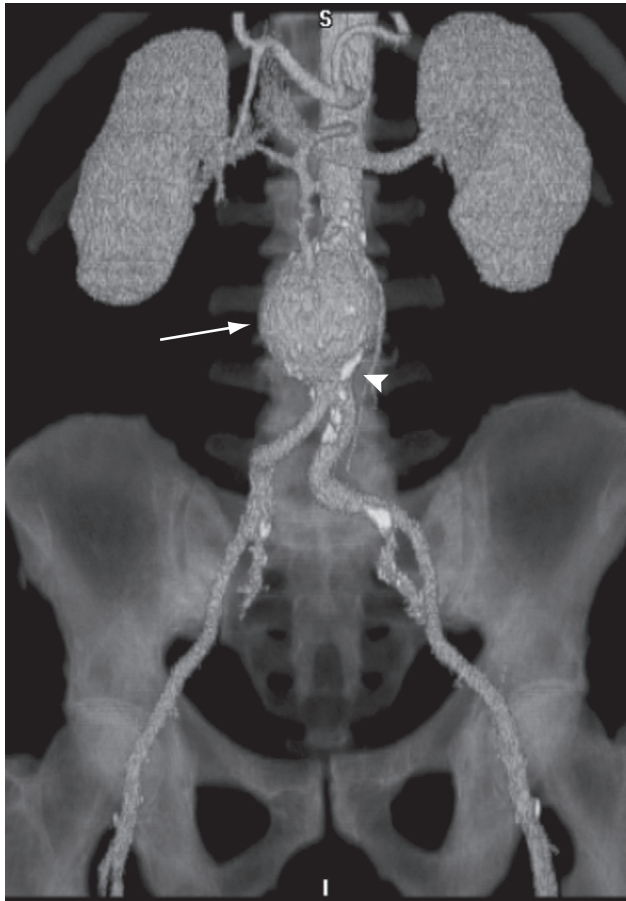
CT angiogram. Reconstruction from many thin axial sections following an intravenous injection of contrast demonstrating an aortic aneurysm (arrow). Calcification is seen in the wall of the arteries (arrowhead).
